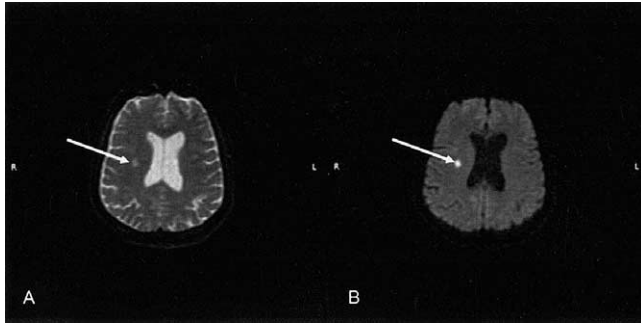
Cerebral magnetic resonance imaging scan in (A) T2- and (B) diffusion-weighted imaging with (arrow) a cerebral lesion after an embolic event.
